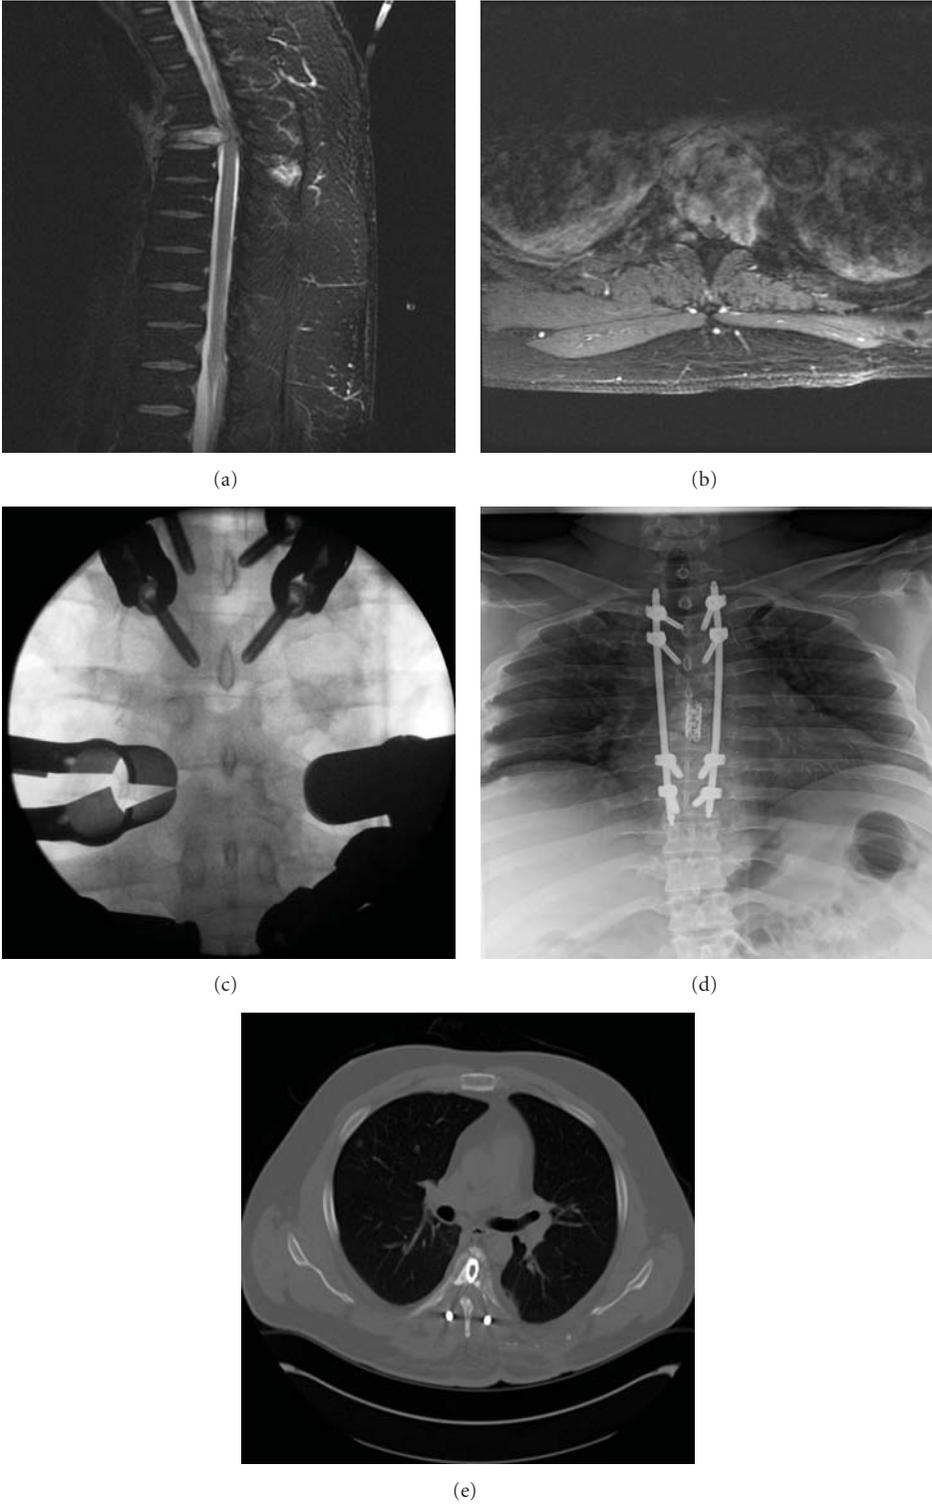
Bilateral extracavitary decompression for metastatic fibrosarcoma. (a) Sagittal T2-weighted, and (b) axial gadolinium enhanced MR images demonstrate pathologic fracture and metastatic epidural spinal cord compression at T5. (c) Fluoroscopy demonstrating docking of extracavitary retractors over the T5 costovertebral region. (d) Postoperative radiograph demonstrating T2-T8 fixation with cage + methylmethacrylate reconstruction of T5. (e) Postoperative CT demonstrates bilateral extracavitary decompression with cage/cement reconstruction.
